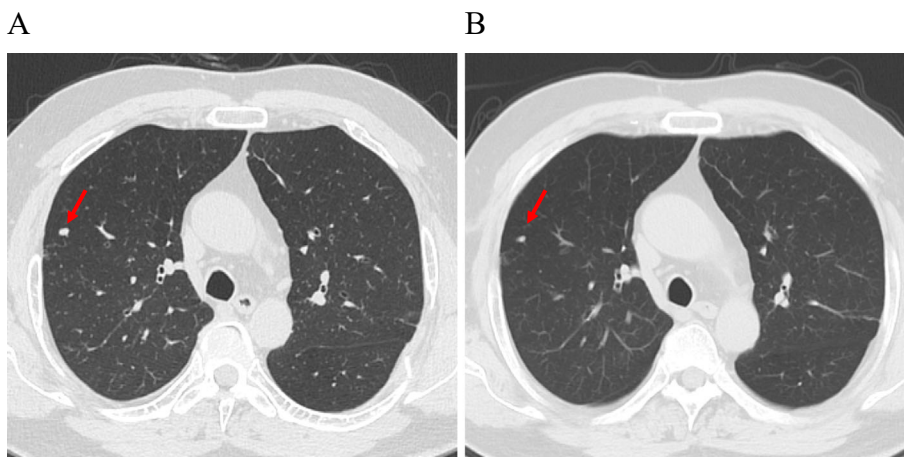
CT scan before (A) and two months after (B) the administration of sorafenib. The nodule in the right lung had shrunk (red arrow), and other nodules also showed a shrinking trend. CT: computed tomography
